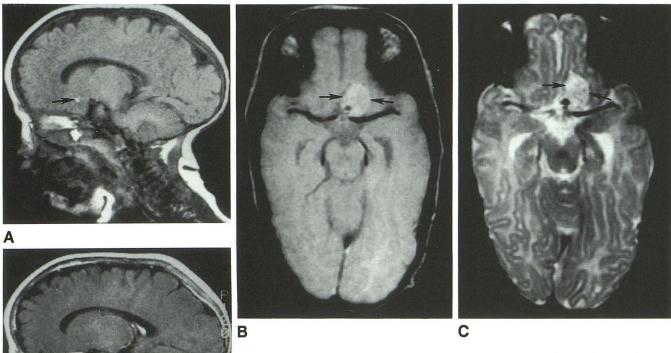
Meningotheliomatous meningioma; 3-month-old infant with sagittal synostosis and cutaneous and hepatic hemangiomas. Sagittal T1-weighted image (600/20, TR/TE) (A) shows dolicocephaly and inferior frontal mass with punctate central hyperintensity (arrow). The mass is hyperintense on proton density (3000/30, TR/TE) (B) and T2-weighted (C) (3000/120, TR/TE) images (arrows). Sagittal (D) T1-weighted postcontrast scan shows intense enhancement of the dural based mass on the left sphenoid wing.
